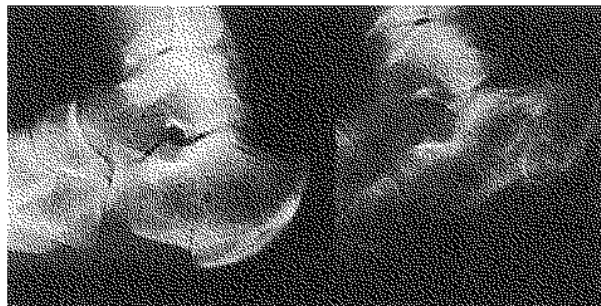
Lateral radiograph of preoperative appearance (left) and at follow-up nine months postoperatively (right).
